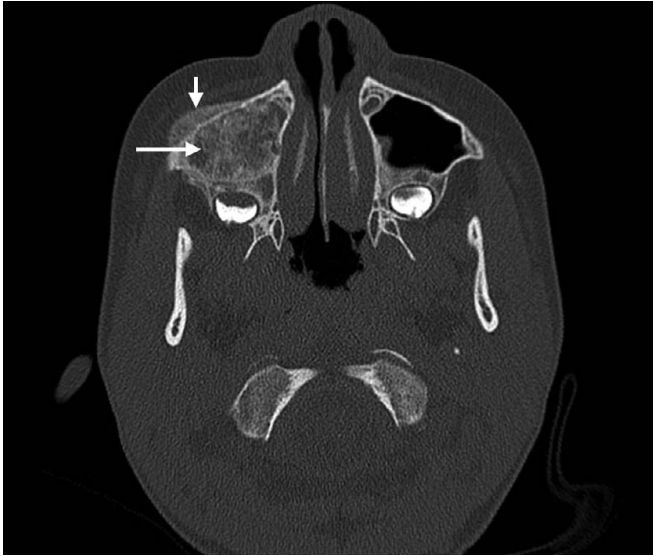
Maxillary sinus osteosarcoma. Axial computed tomography demonstrates soft tissue mass with osteoid matrix filling the right maxillary sinus (long arrow). Periosteal reaction is noted along the anterior maxillary sinus wall (short arrow).
